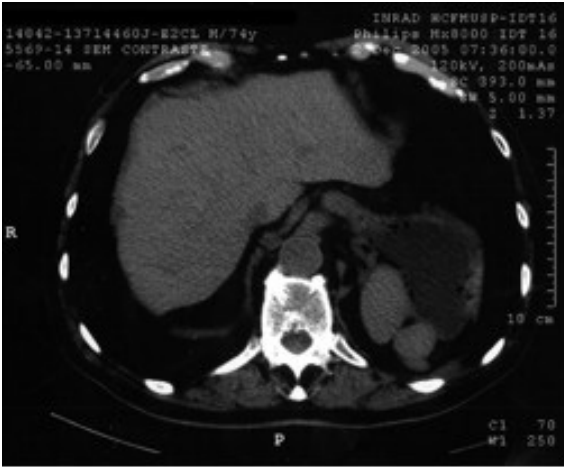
Axial CT scan showing two solid masses attached to the gastric fundus measuring 4,0 and 2,5 cm respectively
